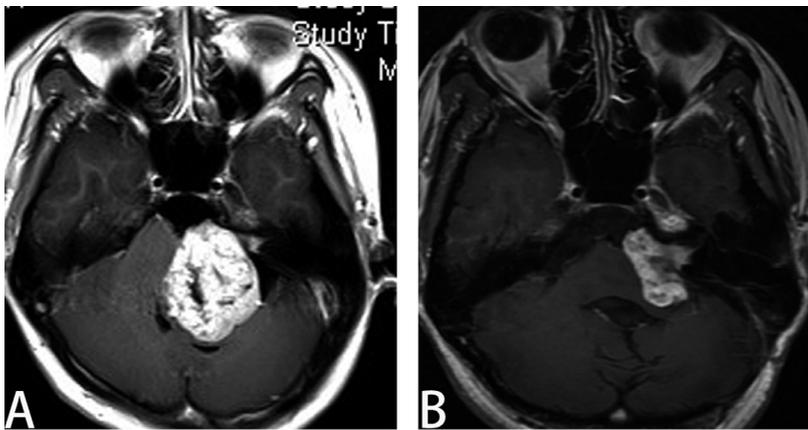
Preoperative and postoperative MR images
